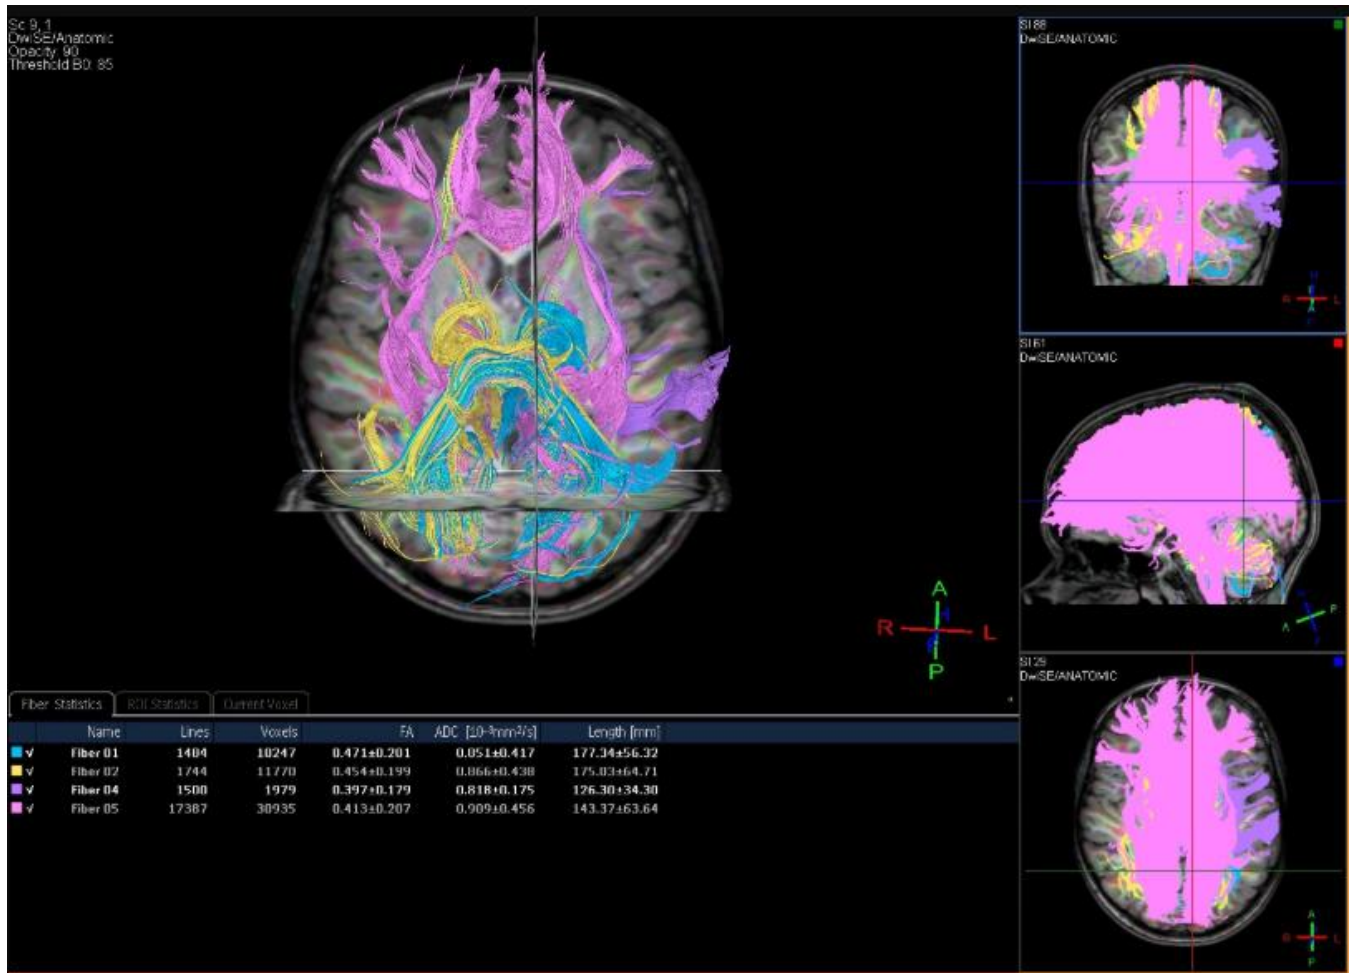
Diffusion tensor MR imaging findings before treatment.
